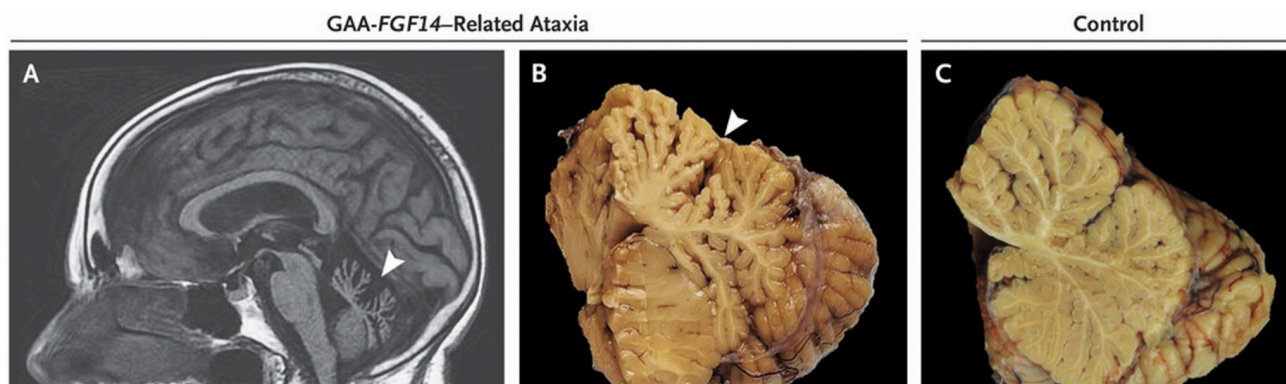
Imaging and Neuropathological Findings in Patients with GAA-*FGF14*-Related Ataxia. A) Severe vermis atrophy (arrowhead) on sagittal T1-weighted magnetic resonance imaging in a female patient at 88 years of age. B) Midsagittal section of the postmortem cerebellum of the same patient at 94 years of age, in which anterior vermis atrophy is visible (arrowhead); C) Age-matched control for comparison. Adapted from Pellerin et al. (2023).
